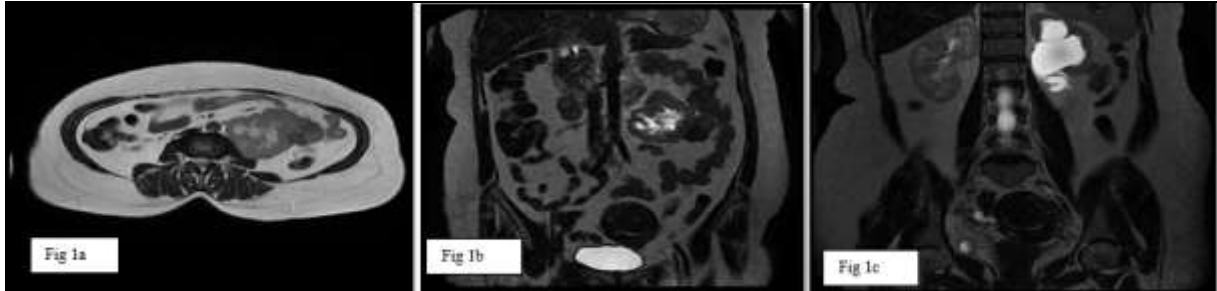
(a, b, c) Axial & Coronal MRI of abdomen and pelvis: Large lobulated mixed intensity (solid and cystic component) soft tissue mass 12x8x5 cms in the retroperitoneum, infiltrating the left ureter resulting in left hydro-ureteronephrosis and the mass is seen to displaced the bowels
